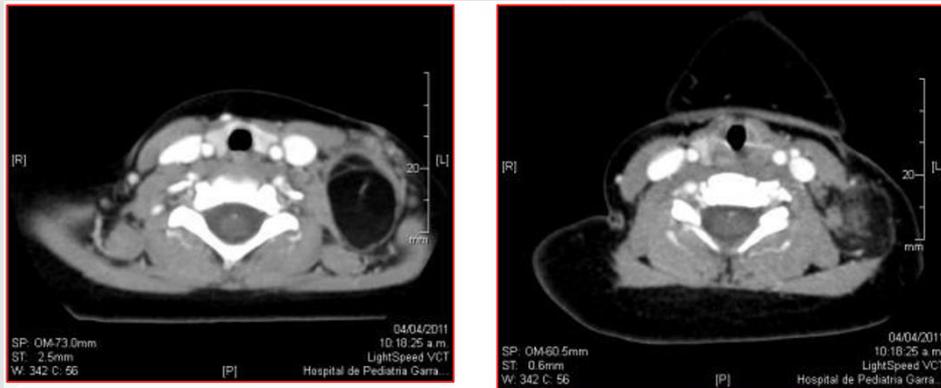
CT Scan showing a big, round, fat-Hounsfield-density, lobulated lesion.
